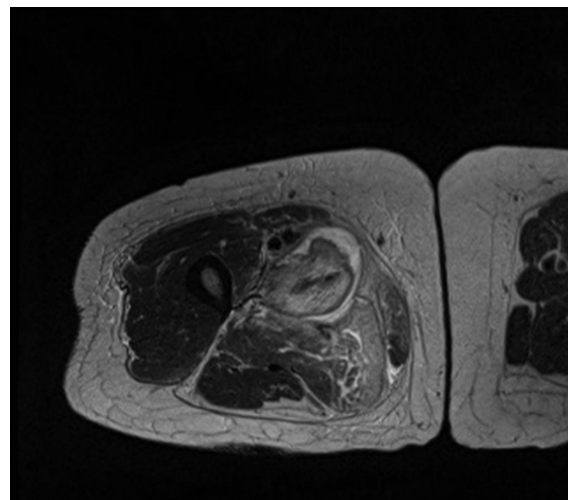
Axial T2-weighted magnetic resonance imaging of the right thigh showing hyperintensities (edema and perifascial fluid) in the adductor muscles.
